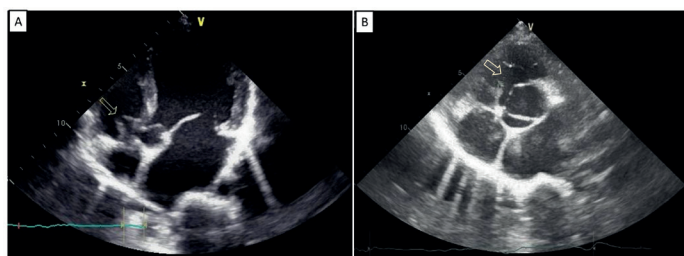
2D echocardiographic images shows windsock shaped sac rupturing at its apex (arrow) into RV in apical 5-chamber view (panel A); Short axis shows aneurysmal right coronary sinus with a defect (panel B)
